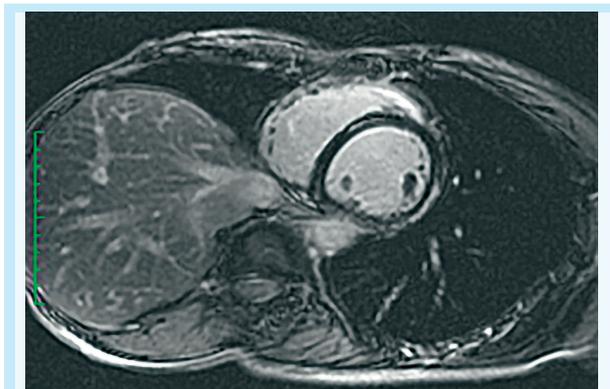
Cardiac MRI showing delayed gadolinium enhancement (DGE) in a non-vascular pattern.
